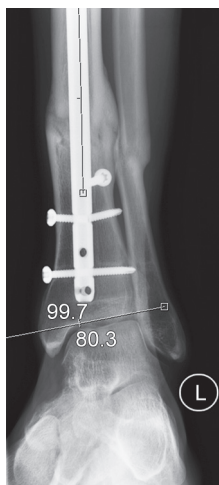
An AP radiograph of the same patient taken 12 months later. It demonstrates an increase in the joint mal-orientation and a broken locking bolt
